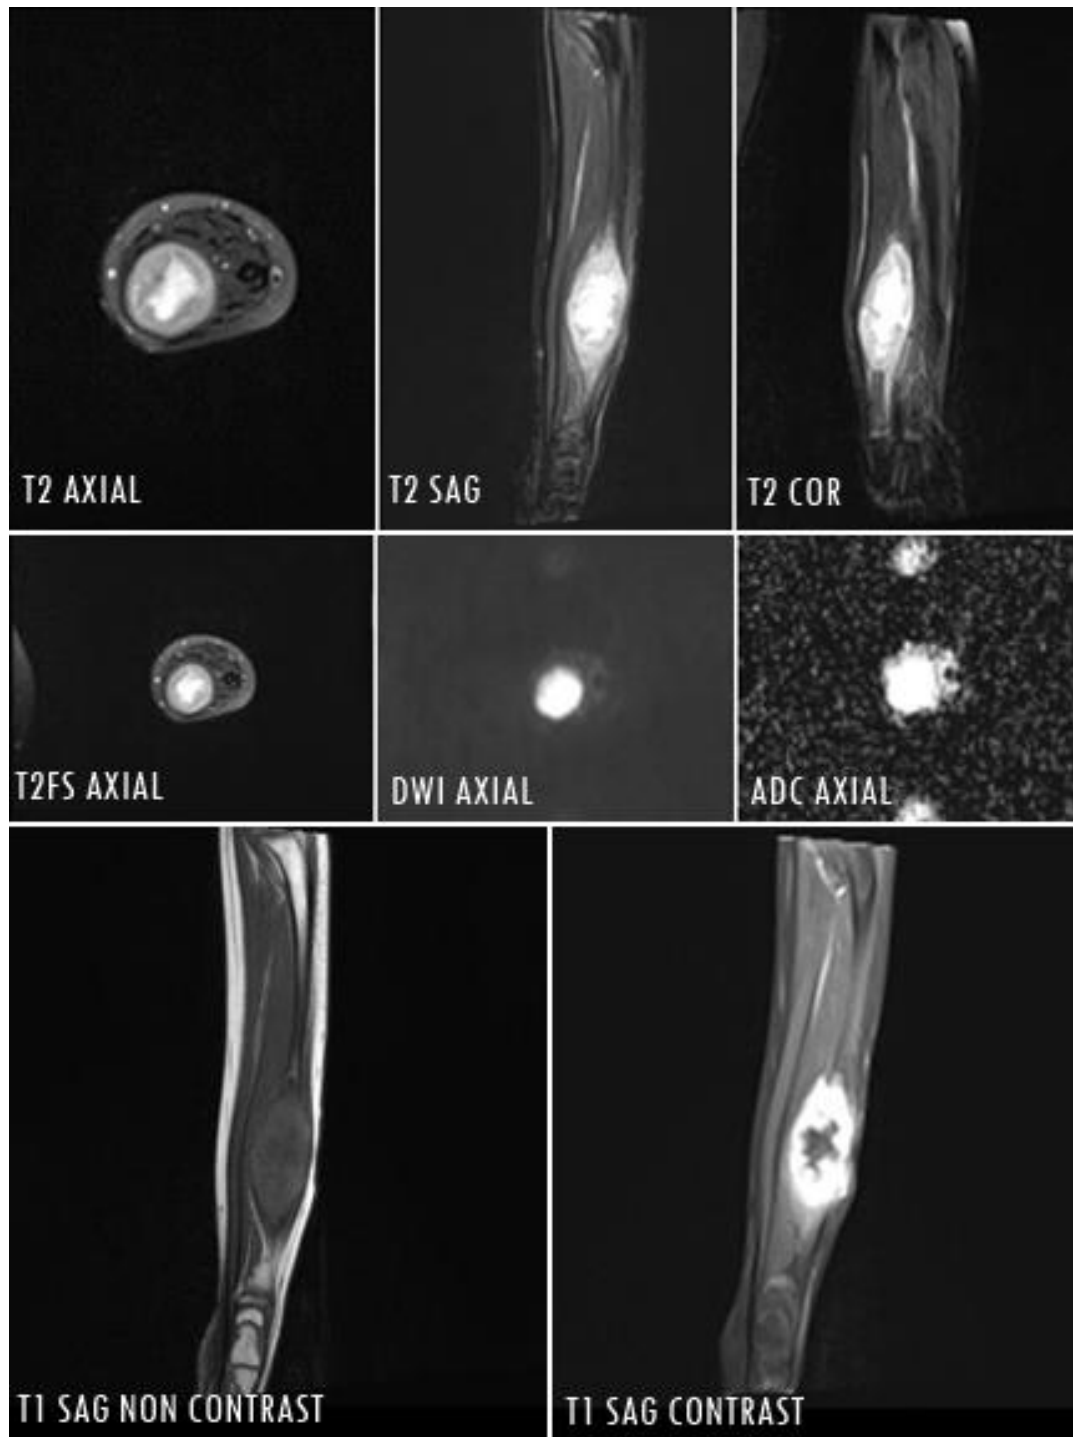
Left antebrachii MRI
